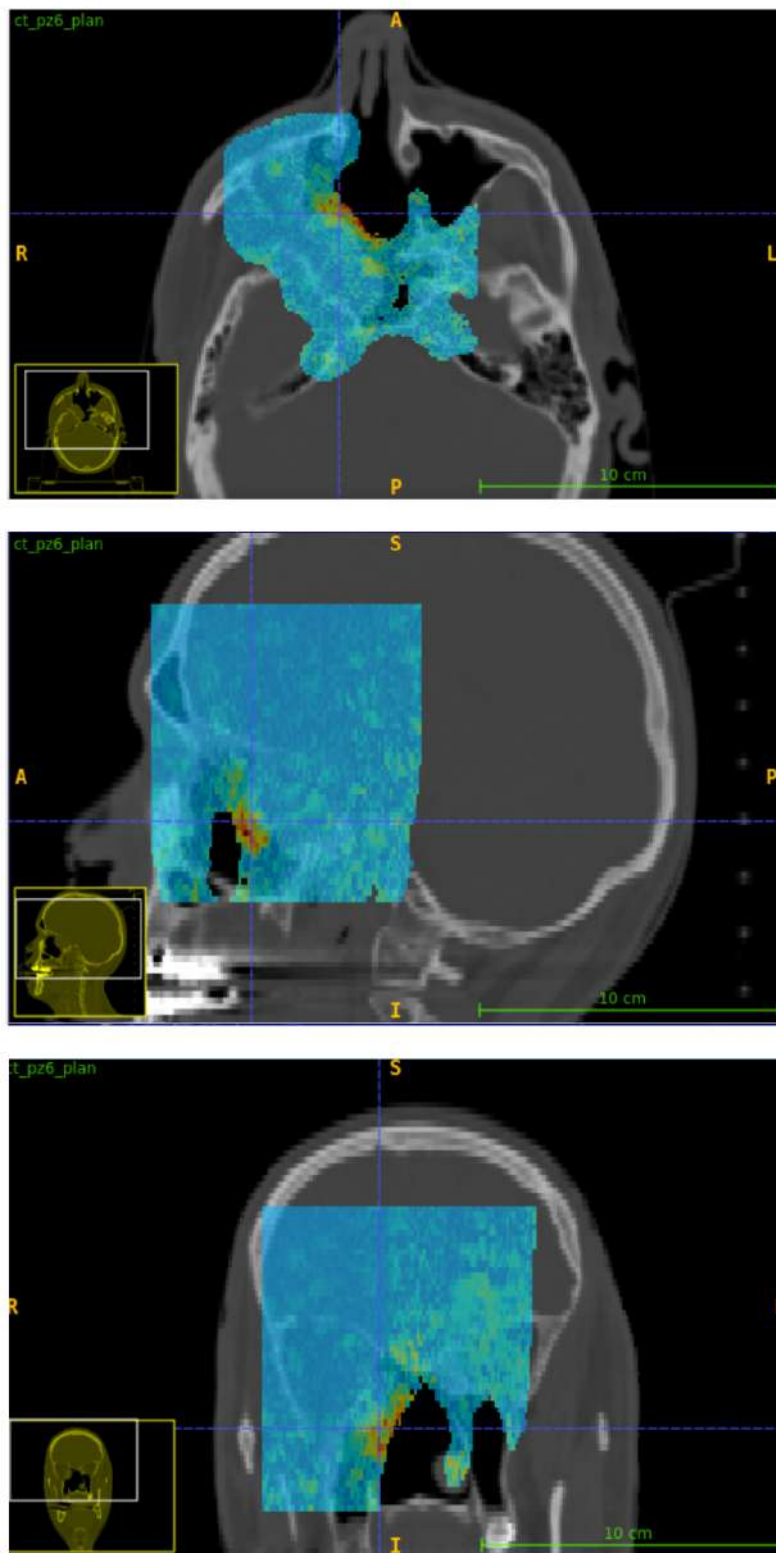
Gamma mode map for  $DD = 55\%$ ,  $DTA = 8 \text{ mm}$ ,  $DTH = 0.5\%$  in axial, sagittal and coronal views (from top to bottom), overlaid on the planning CT.
